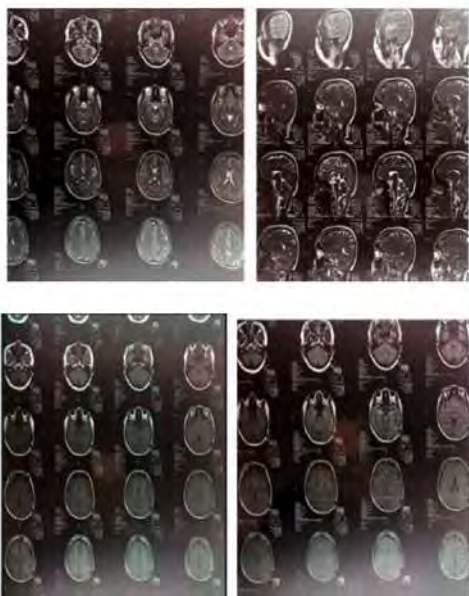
Cerebral MRI Leukoaraiosis
